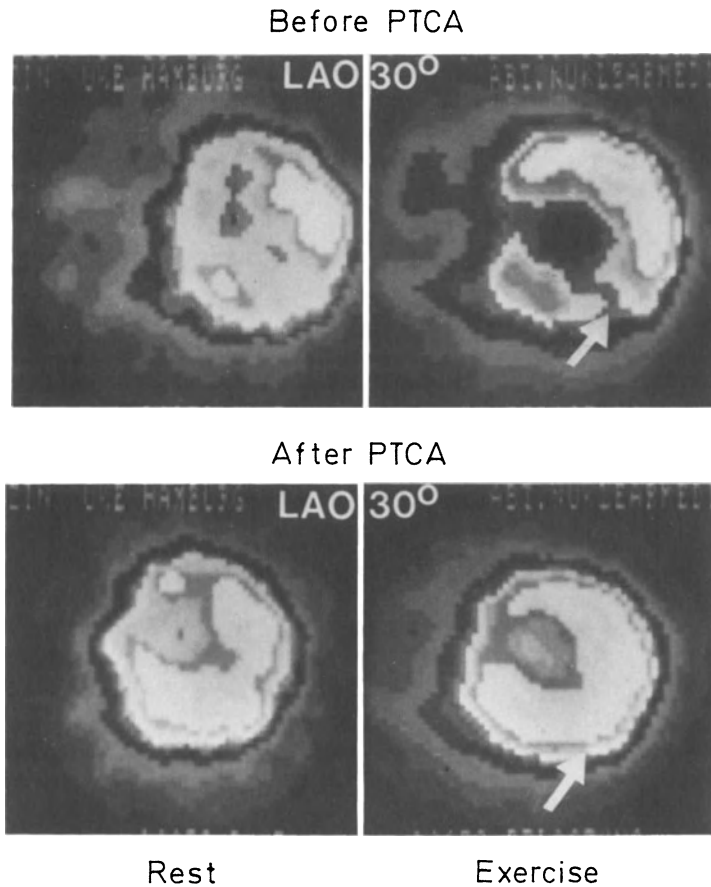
^{201}Tl scintigrams of exercise-induced hypoperfusion indicative of transient ischemia in the inferior left ventricular wall. After successful PTCA, normal perfusion pattern was restored at rest and during exercise
